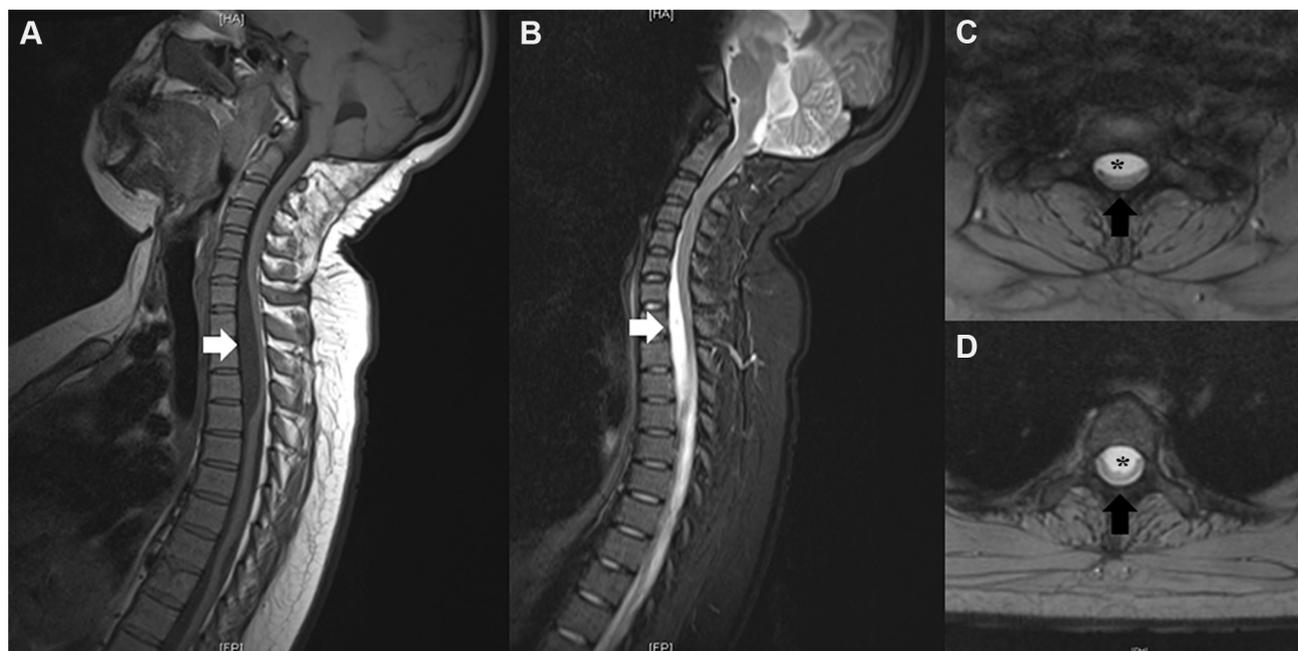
Sagittal T1 (A) and T2 (B) magnetic resonance images showing a large intradural cystic cavity (white arrows) extending from C6 to T4, located ventral to the cord, which is severely pushed backward. Axial T2
